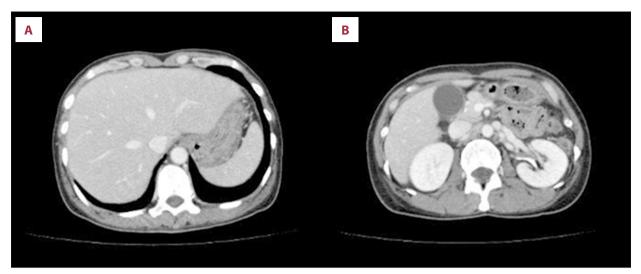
(A, B) Computed tomography of the abdomen. Abdominal computed tomography showed no findings of hepatosplenomegaly, cholecystitis, cholangitis, or a liver mass, including abscess.
